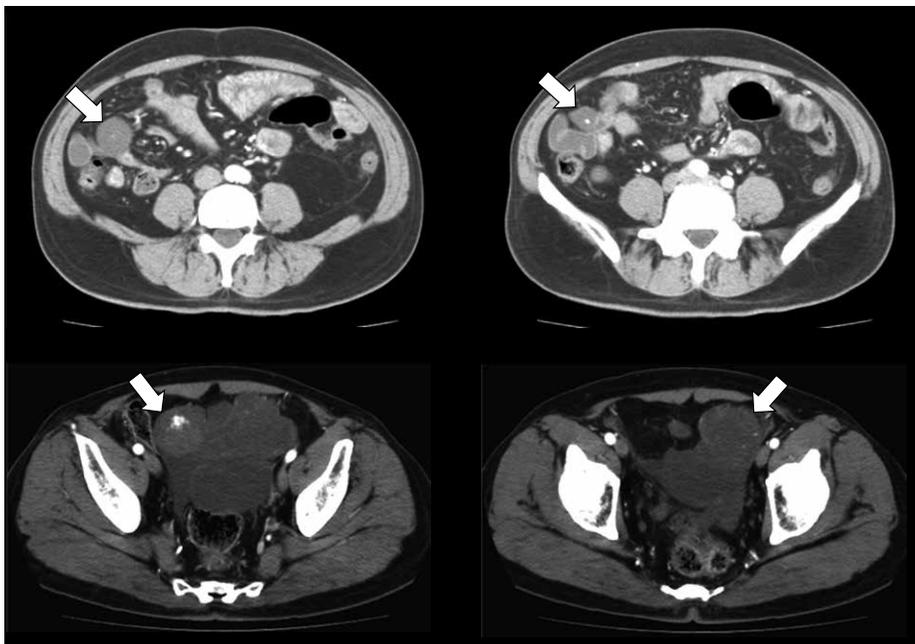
Three years later, follow-up CT showed multiple disseminated lesions (white arrows) and a part of the intrapelvic primary tumor was suspected to be viable.
